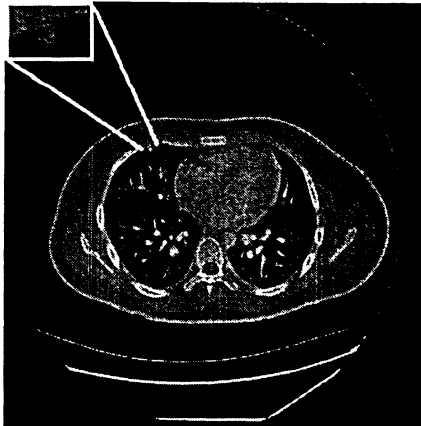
(a) Original pulmonary CT image. (b) Segmented lung borders. (c) Smoothed lung borders. (d) Lung regions.
